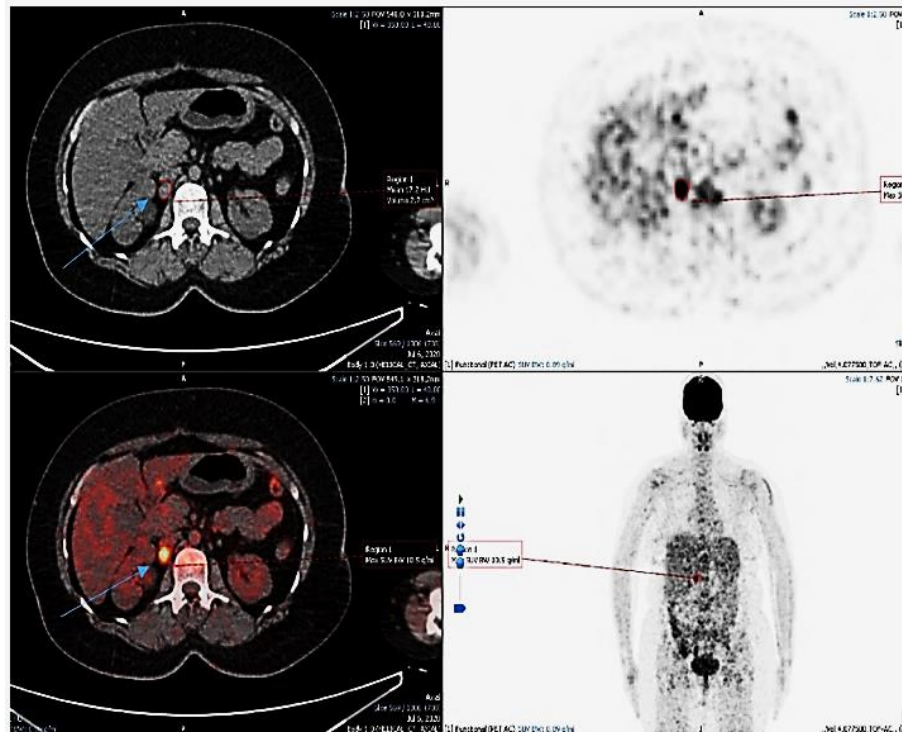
A 30 years old known ovarian carcinoma patient, PET/CT showing hypermetabolic right paracaval lymph node (blue arrow) which is the cause of raised CA-125 levels. It is not well appreciated on CT scan and can easily be missed
